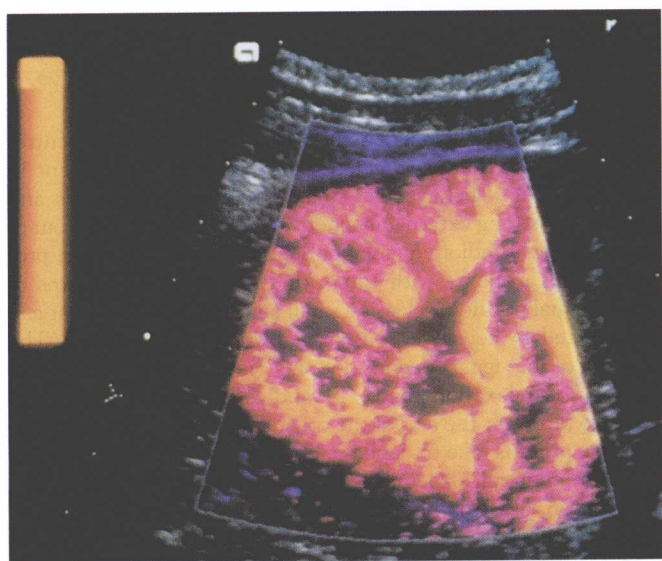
Power Doppler perfusion scan of kidneys.
